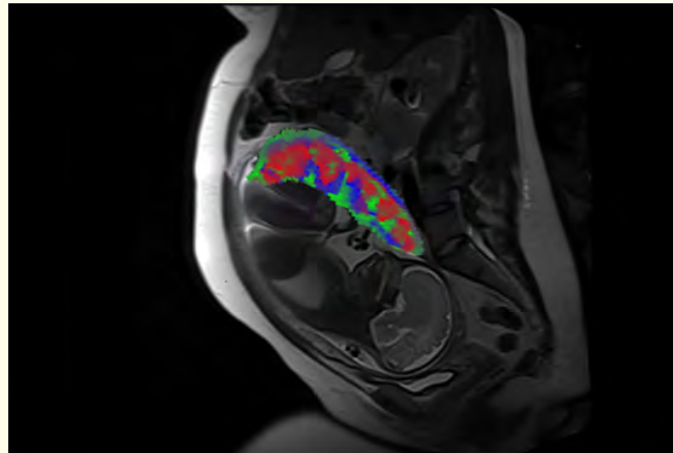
MRI scan showing the fetus and placental compartments-intervillous space (red), placental vessels (green), and placental tissue (blue). Credit: Wang Lab, Washington University in St. Louis.
